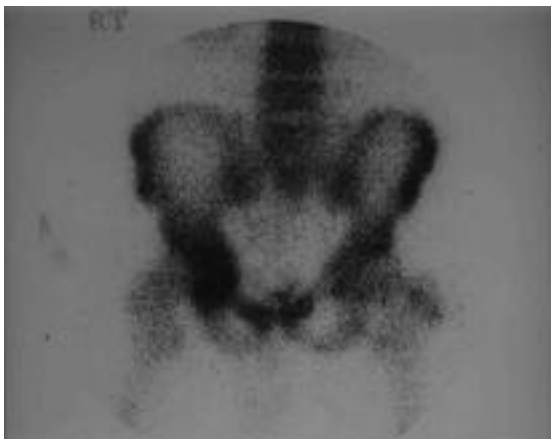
Bone scintigraphy shows increased uptake in the acetabulum.
